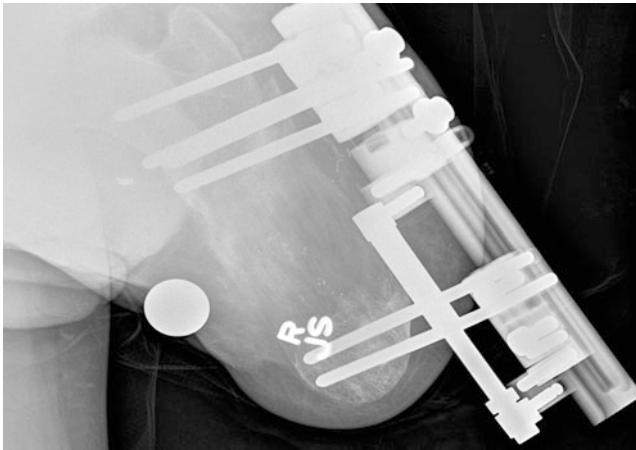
Lateral X-ray at the end of lengthening phase
